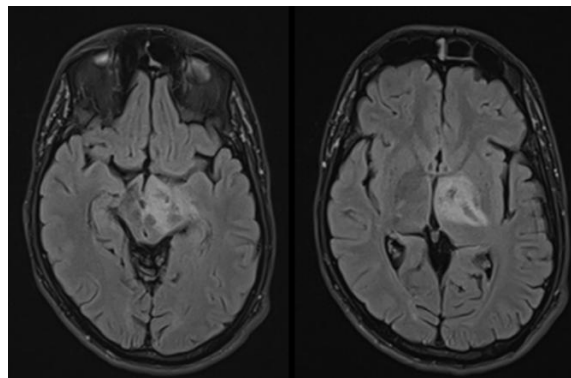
Axial brain MRI FLAIR sequence showing a hyperintense lesion involving the mesencephalic and diencephalic regions in a 34-year-old male patient diagnosed with Behçet’s disease.
